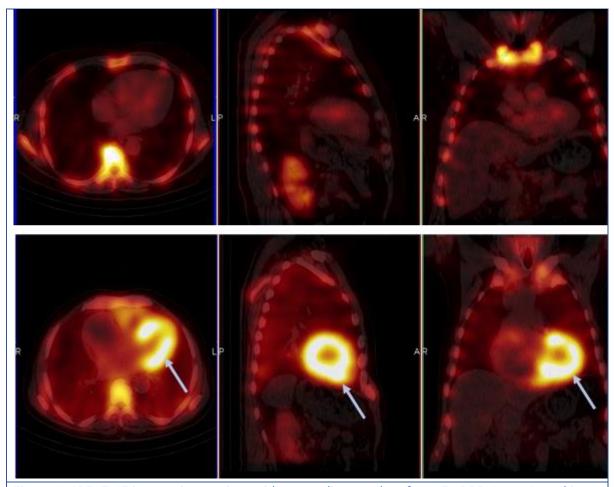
SPECT-CT images in a patient with no cardiac uptake of 99mTc-DPD (upper); and in a patient with intense 99m Tc-DPD uptake (lower). Arrows indicates cardiac 99m Tc-DPD uptake.
